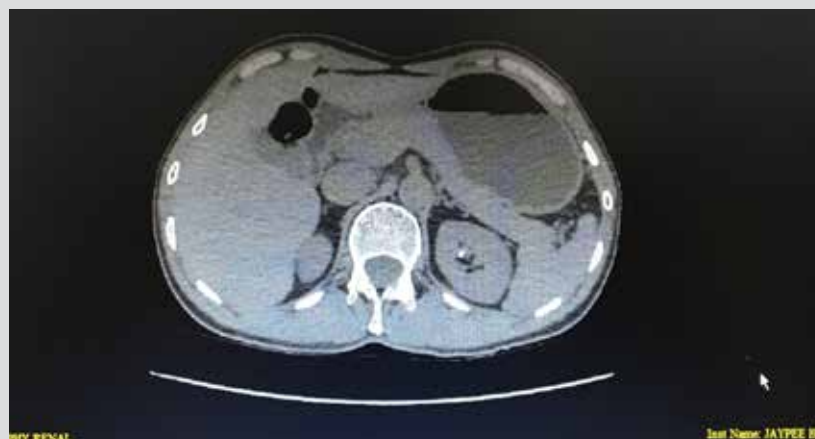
Computed tomography scan demonstrating a small 4-mm non-obstructive renal stone
